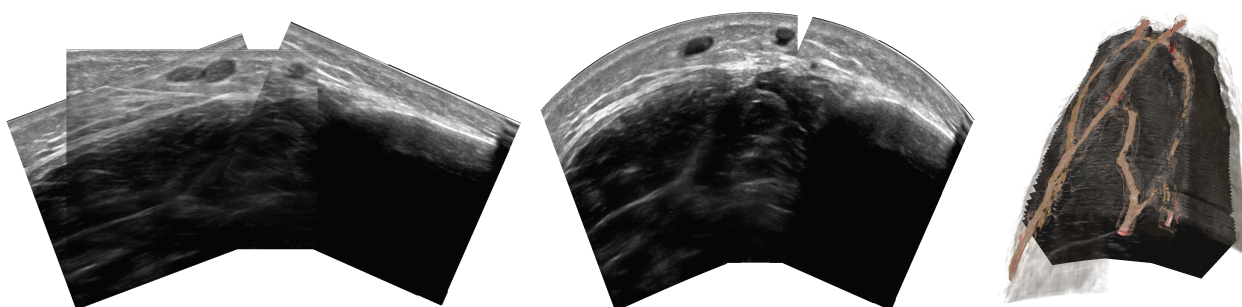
Application of our technique to vascular ultrasound. Due to tissue compression artifacts the original acquisition (left) exhibits poor alignment of important anatomical features. For instance, the same vessel is shown twice at different locations. Our decompression and image stitching technique estimates the original shape of the anatomy and provides a plausible extended FOV reconstruction of the anatomy (middle). This can for instance be used for showing the whole vessel tree (right) providing important spatial context.
